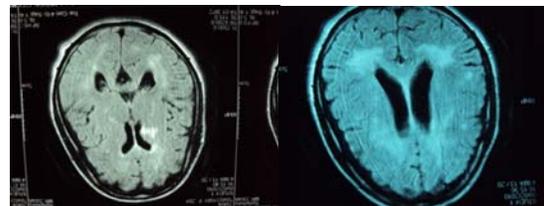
MRI with pre-ventricularleuco-encephalopathy.
